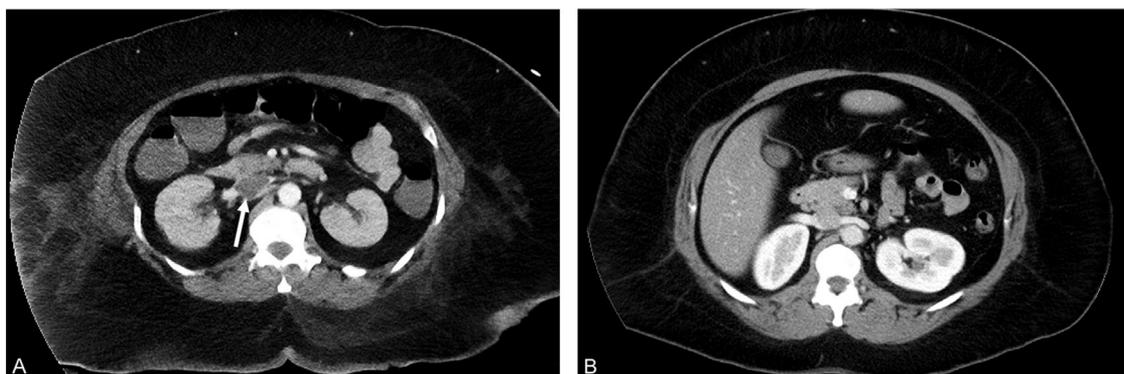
Missed inferior vena cava (IVC) thrombus on contrast-enhanced CT (CECT). (A) A 56-year-old woman with acute abdominal pain. Low density clot in the IVC (white arrow) was part of extensive iliofemoral thrombus. Note the sharp margins of the clot. (B) A 43-year-old man with abdominal pain. On AP CECT there is mixing artifact in the IVC as opacified blood returns to the IVC from the renal veins. Note the similarity to clot in [Figure 2A](#).
